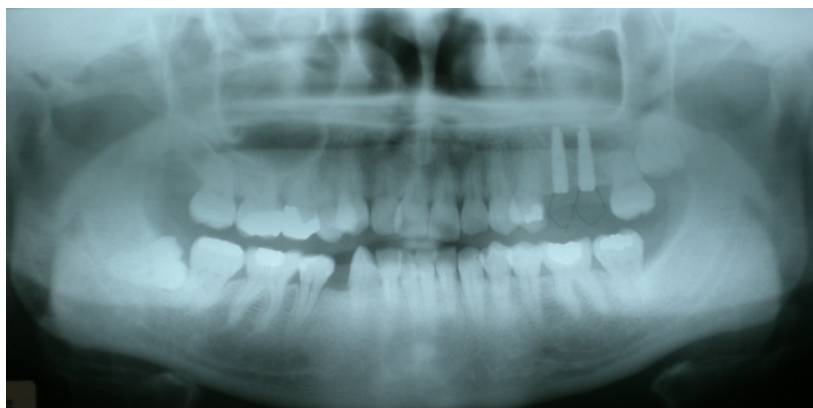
Postoperative radiographic view
